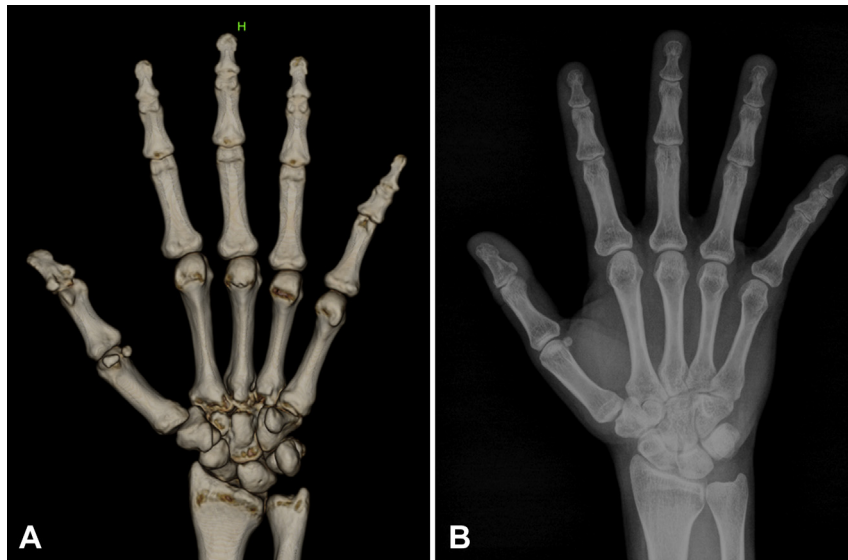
Evaluation of images. (A) Typical 3D-reconstructed CT image (B) Antero-posterior X-ray of the hand.
